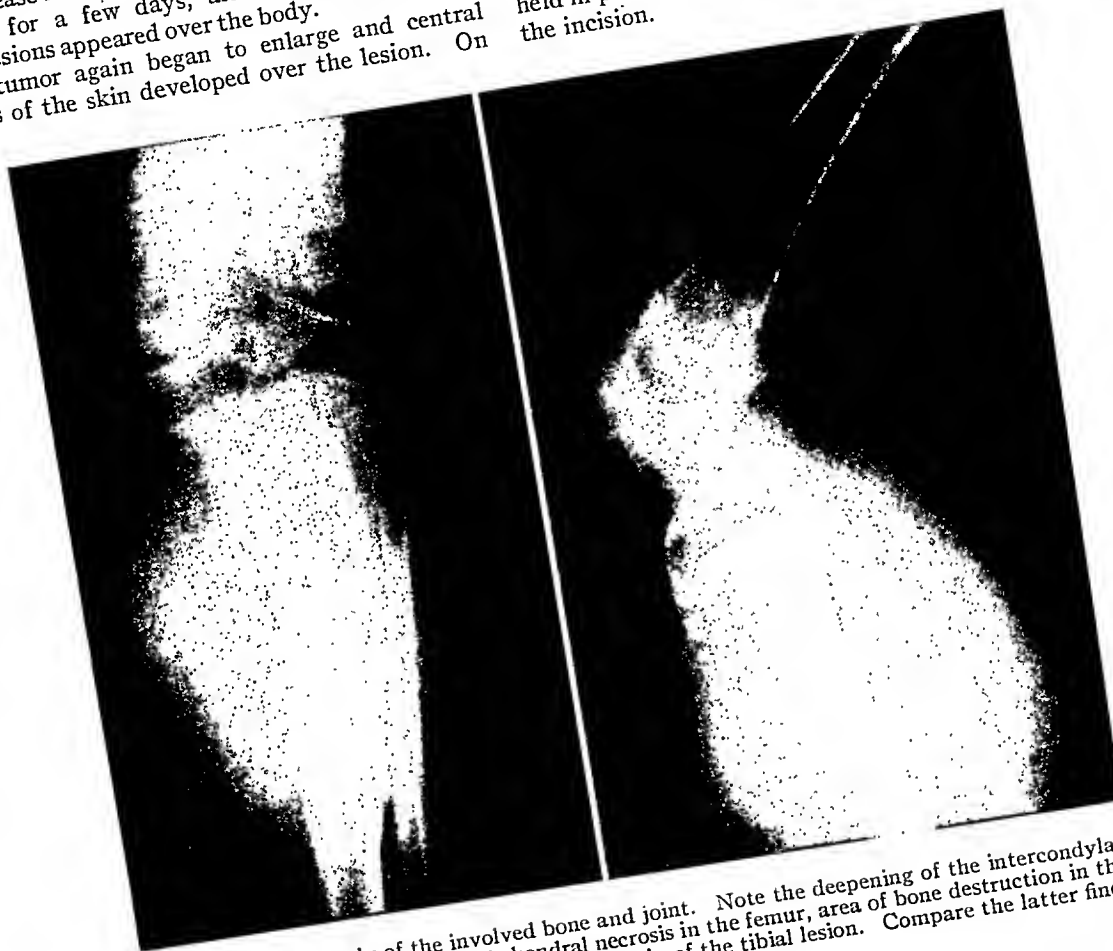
X-ray study of the involved bone and joint. Note the deepening of the intercondylar notch of the femur, the areas of subchondral necrosis in the femur, area of bone destruction in the tibia, and the periosteal "cuff" on the lower margin of the tibial lesion. Compare the latter findings with those in Fig. 3.
